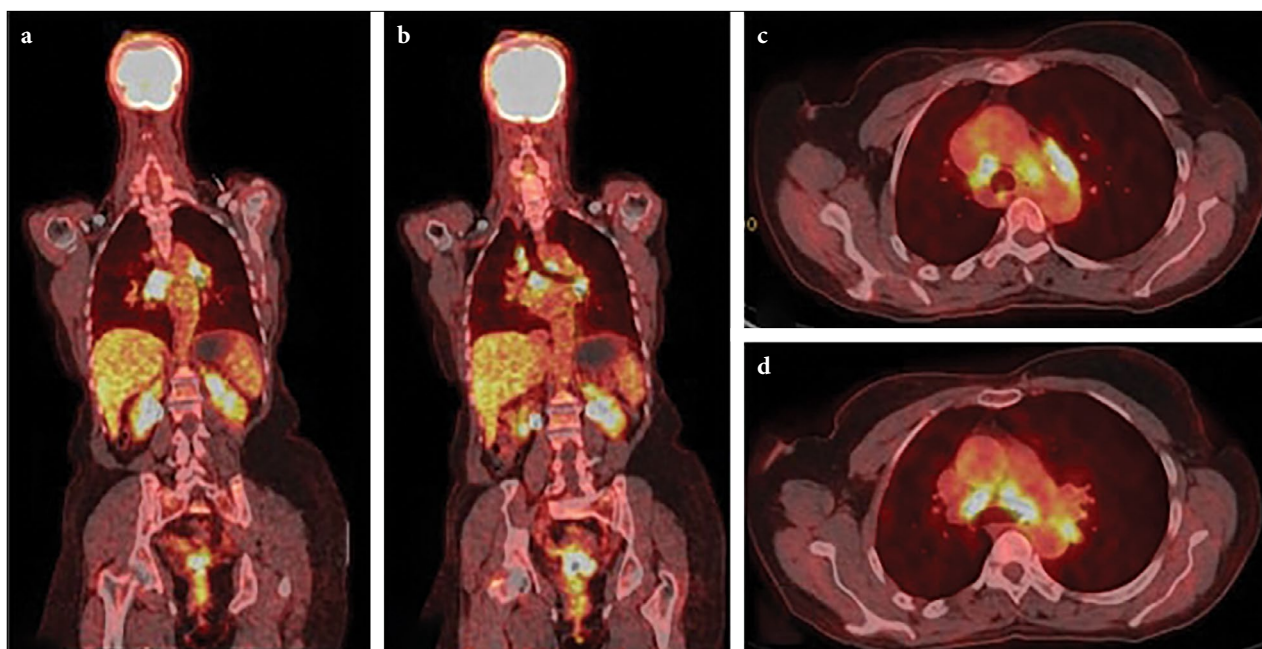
Whole body FDG-PET/CT showing FDG uptake on mediastinal and hilar lymph nodes, on the coronal images (a,b); as well as on the transverse images (c,d).
